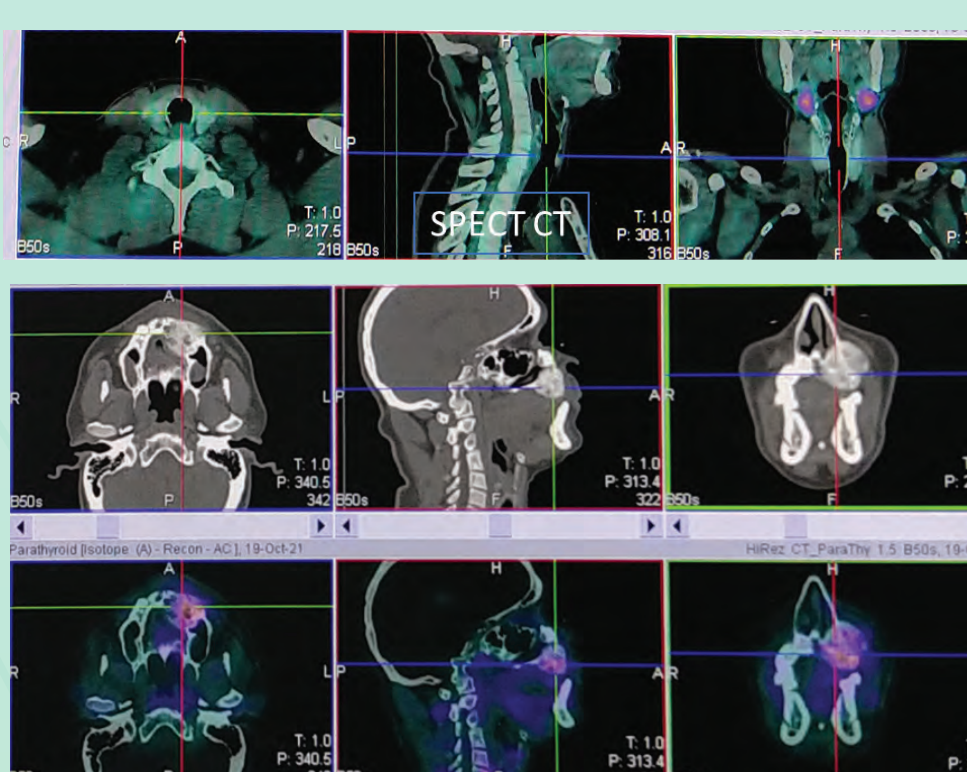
^{99m}Tc-MIBI Parathyroid SPECT CT was negative for parathyroid adenoma (upper row). Focal increased radiotracer uptake at the bony lesion of left maxilla (lower row).
